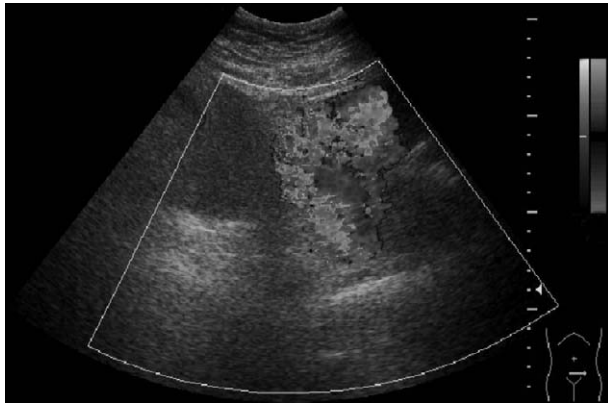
Abdominal sonogram shows an aneurysmal dilatation of the pelvic vein beside the urinary bladder.
